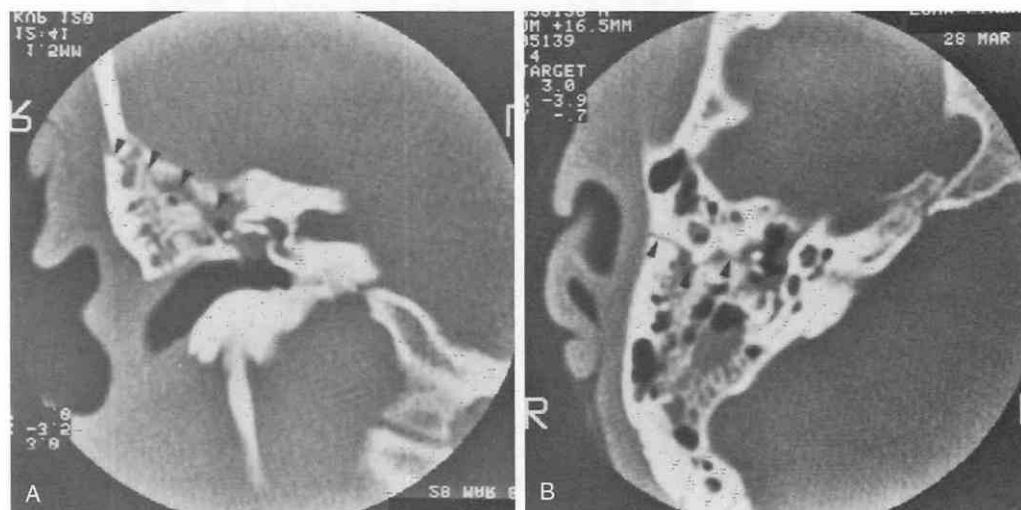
Longitudinal fracture in a young man presenting with right-sided conductive hearing loss following skull trauma. Coronal (A) and axial (B) CT scans of the right temporal bone show a fracture line (arrowheads) extending obliquely from the superior lateral portion of the mastoid air cells into the tympanic cavity. There is patchy air-fluid level opacification of the tympanic cavity and mastoid air cells because of hemorrhage and fluid. The ossicles are not displaced.
